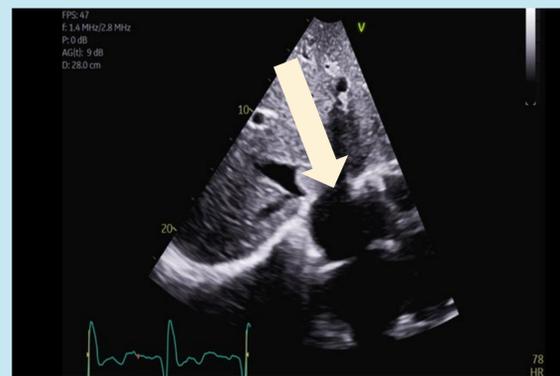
Transthoracic echocardiogram subcostal view revealed mobile echodensity 1.7 cm x 2.4 cm (arrow) at the junction of the inferior vena cava and the right atrium.
